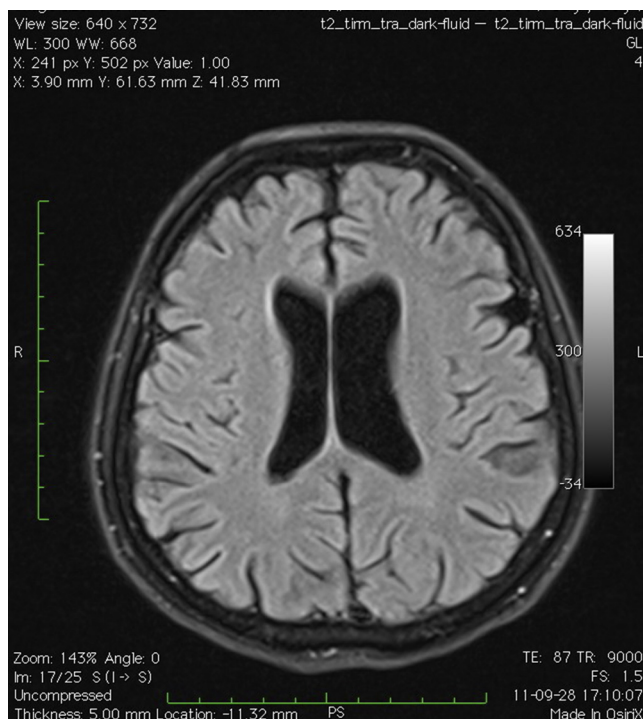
Control MRI of the brain (FLAIR weighted image), 1 year later: disappearance of previously described lesions.
